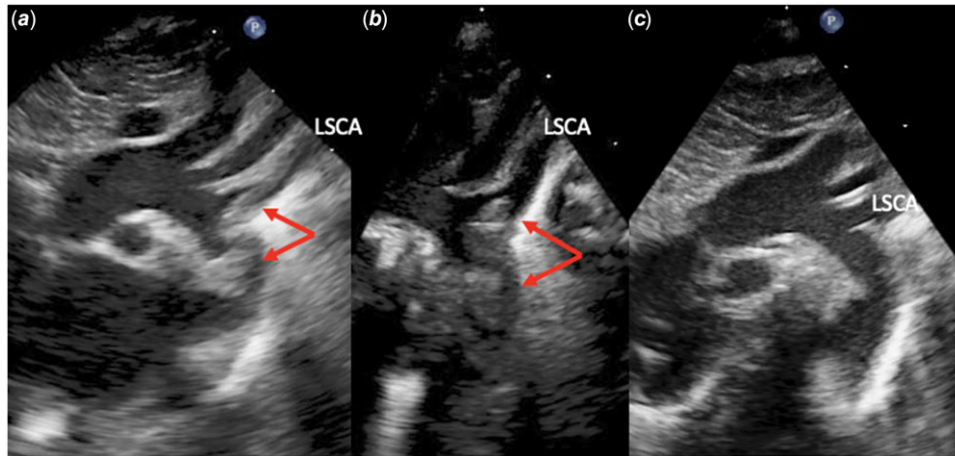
(a and b) Transthoracic echocardiography, suprasternal notch view at the presentation and post-thrombectomy (c). There was echo-bright structure at the aortic isthmus, extending to the left subclavian artery. Post-thrombectomy, there was no obvious obstructive structure observed in the proximal descending aorta or LSCA.
